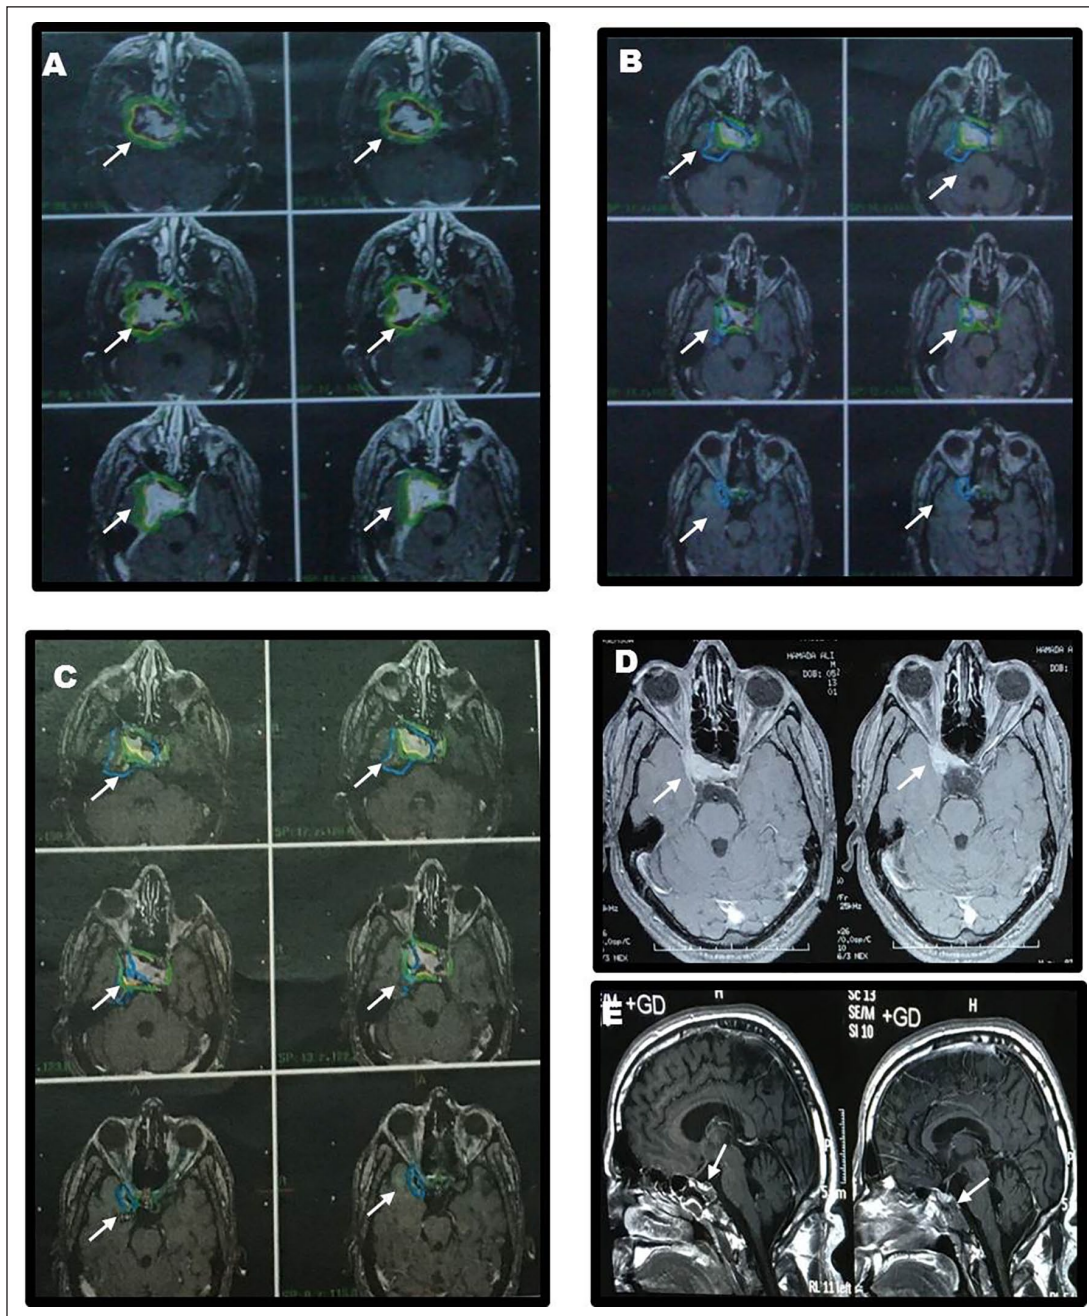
Follow-up MRI-brain scans showed significant reduction of the tumor size after GKRS (3.9X3X3 cm) [Dates: 08/13/2016 (B), 01/31/2017 (c), 05/15/2017 (D) and 01/29/2018 (E)] compared to his initial scan (4.1X4X3.5 cm) [Date: 08/15/2015 (A)].
